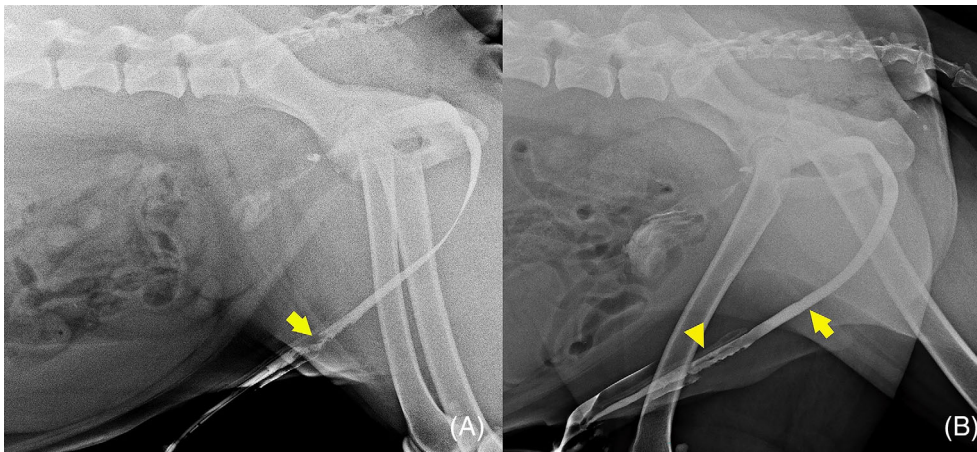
(A) A penile urethral stricture at the bulbus glandis (arrow) was identified on a lateral retrograde positive contrast urethrograph. No leakage along the urethral graft area was identified via positive contrast radiography 6 months after surgery. (B) The diameter of the buccal mucosal graft urethral segment (yellow arrowhead) is compared to the adjacent urethra (yellow arrow).
